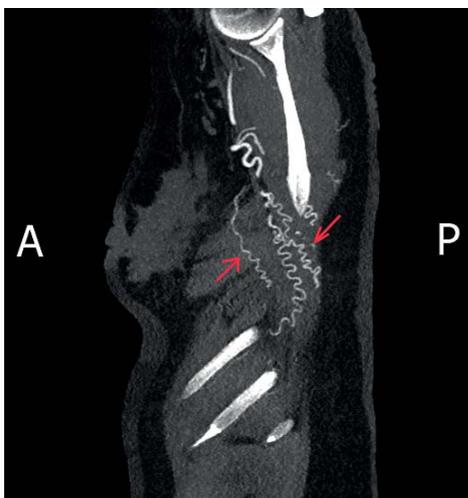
CT scan of thorax (sagittal plane). Collateral vessels provide an alternative source of blood supply to the upper extremities (red arrows)
